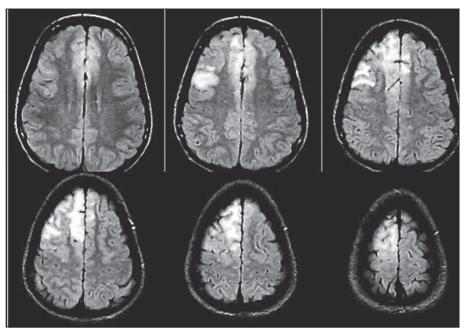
Bilateral Rasmussen syndrome: confluent and subcortical FLAIR/T2 hyperintense lesions in the right upper frontal pre-motor region with partial collapse of surrounding arachnoid spaces. After 10 months, there was contralateral involvement.
